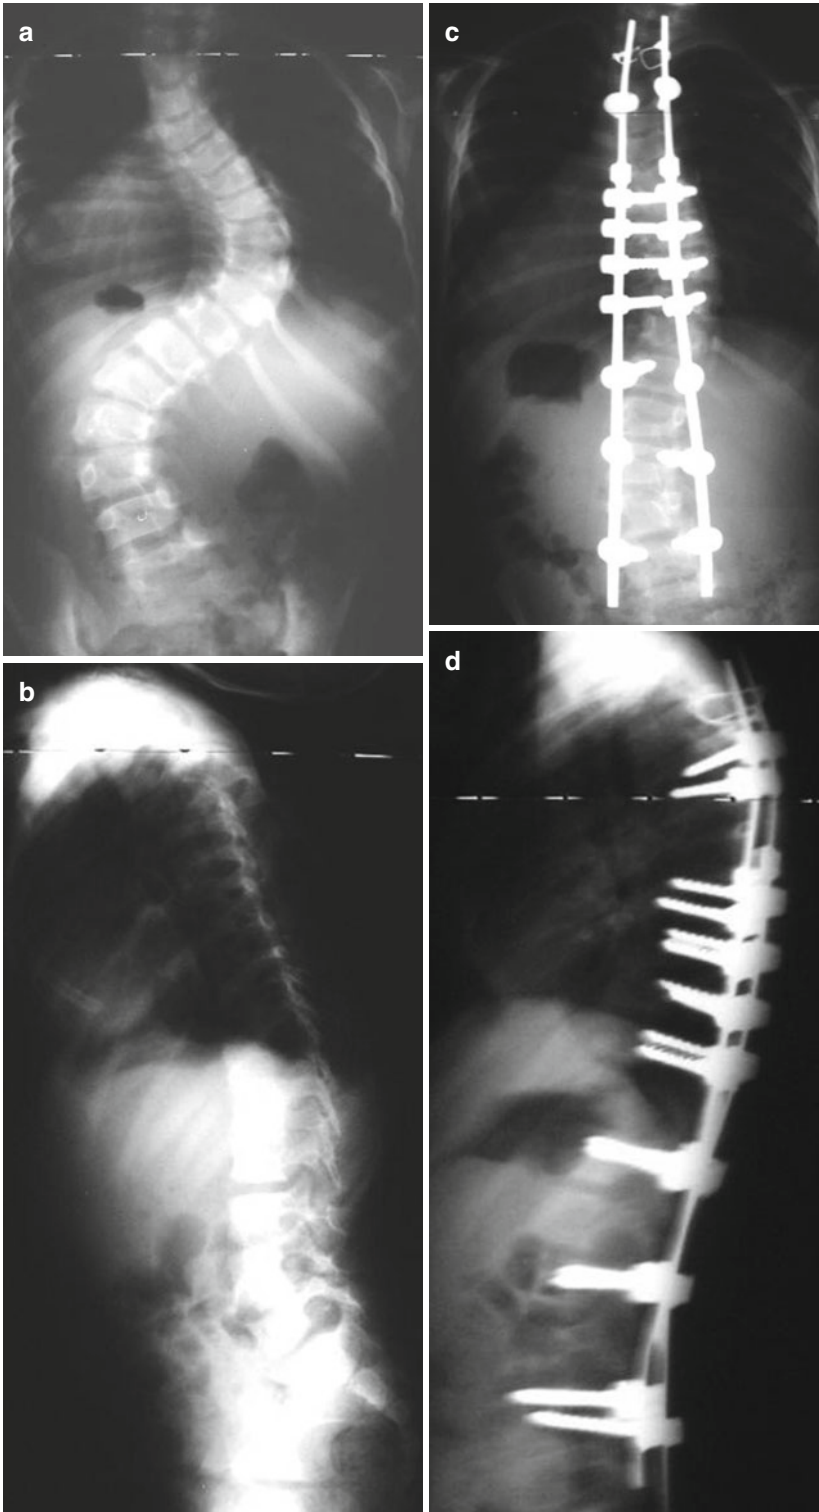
(a–d) Preoperative (a, b) and postoperative (c, d) standing AP and lateral radiographs of a 4-year-old with Marfan’s and scoliosis treated with Shilla procedure
